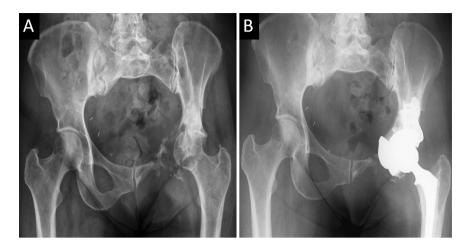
Radiography images. Preoperative (A) and postoperative radiograph (B) of a patient with a history of periacetabular metastatic disease, causing pain and functional limitation after a previously performed subtotal sacrectomy for chordoma. Improvement in Harris Hip Score was achieved following total hip arthroplasty.
